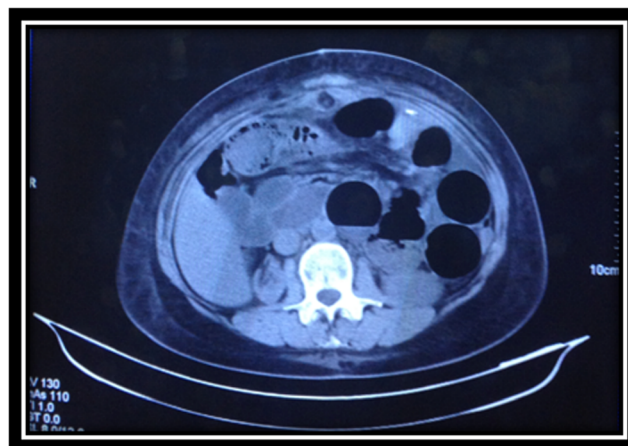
Computed tomography of the abdomen showed dilated loops of small bowel in the left hypochondrium and fluid-air levels
